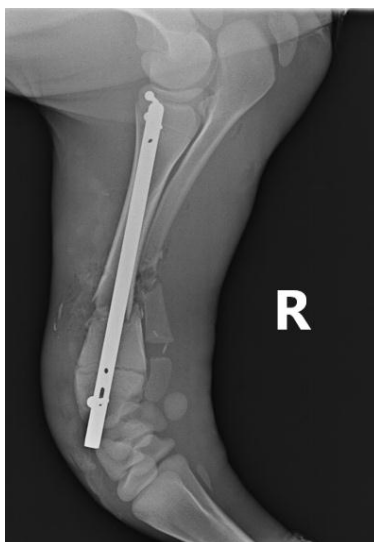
Immediately postoperative radiographs of case 14. The diaphyseal fracture has been repaired using an 8-160-mm interlocking nail. Medio-lateral position.
